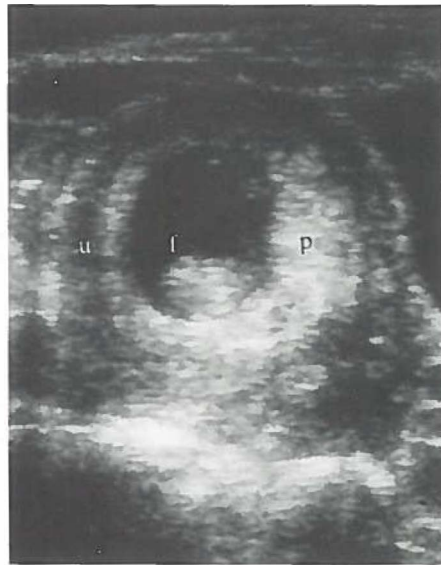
Longitudinal ultrasound scan at intake (9 weeks and 2 days gestation) showing anteverted uterus (u), anterior placenta (p) and fetal parts (f).
